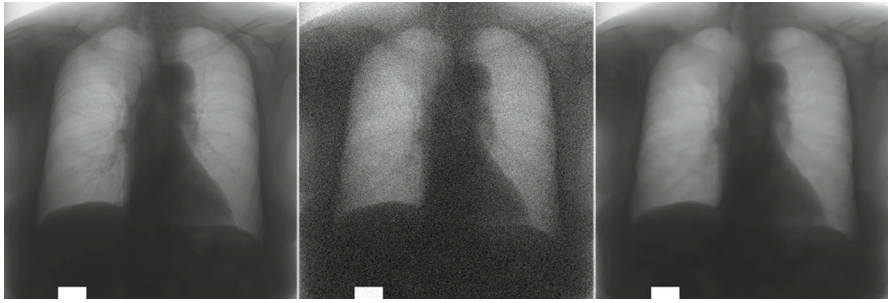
(Chest radiography) model performance trained with  $64 \times 64$  image size. The *first column* is the original image, the *second column* is the noisy image, and the *third column* is denoised image with  $\sigma = 15$
